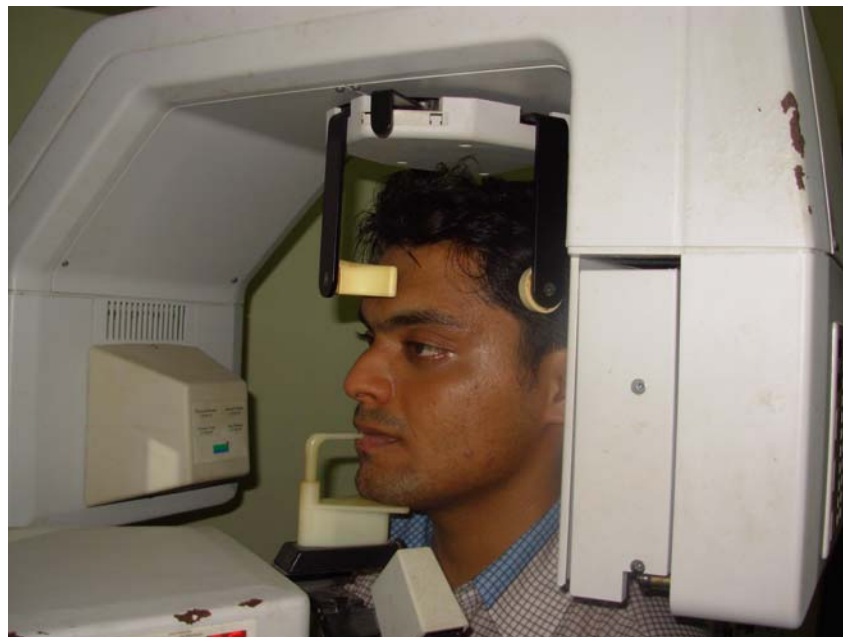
Obtaining the panoramic radiograph of the dentulous subject
